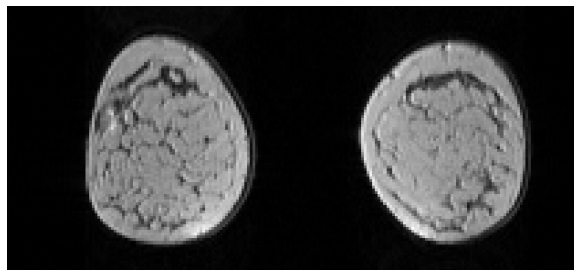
A postcontrast DCE-MRI slice
